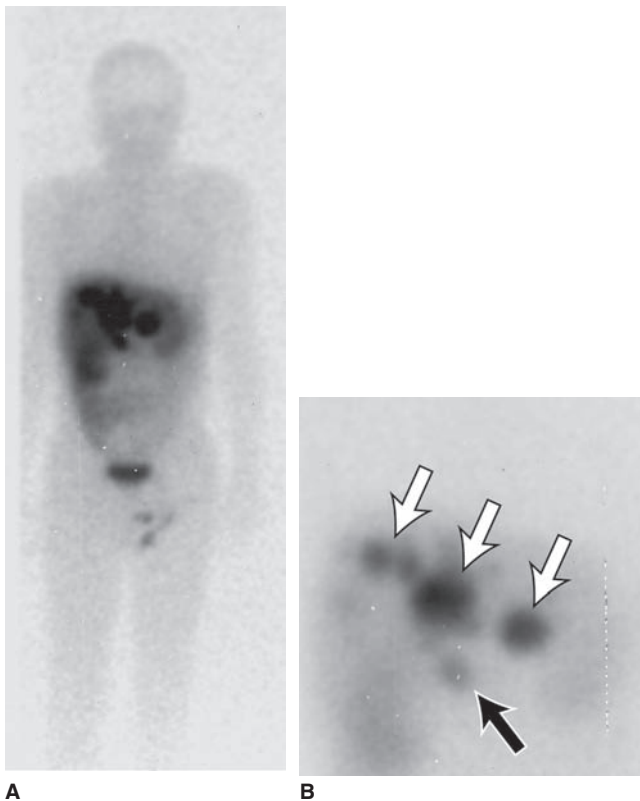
Somatostatin receptor scintigram of a patient with metastatic gastrinoma. A. Whole-body scan at 24 hours after injection of ^{111}In octreotide shows metastatic tumor in the liver with primary tumor in the head of the pancreas. B. Detail of hepatic metastases with pancreatic primary. *White arrows* denote hepatic metastases. The *black arrow* indicates the primary tumor in the pancreas. (From Thompson JC. Endocrine pancreas. In: Townsend CM, Jr, Beauchamp RD, Evers BM, Mattox KL, eds. *Sabiston Textbook of Surgery: The Biological Basis of Modern Surgical Practice.* 17th ed. Philadelphia, PA: Elsevier Saunders; 2004:1001–1022, with permission. Copyright Elsevier 2004.)
